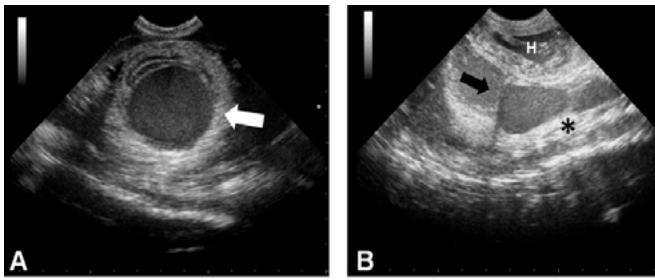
Ultrasonograms of a male Burmese python (*P. m. bivittatus*). a) Multiple layers mass filled with heterogeneous fluid (white arrow) inside the right atrium. b) The heart (H) was ventrally displaced. Note thickening of pericardium (asterisk) and the pericardial effusion (black arrow).
